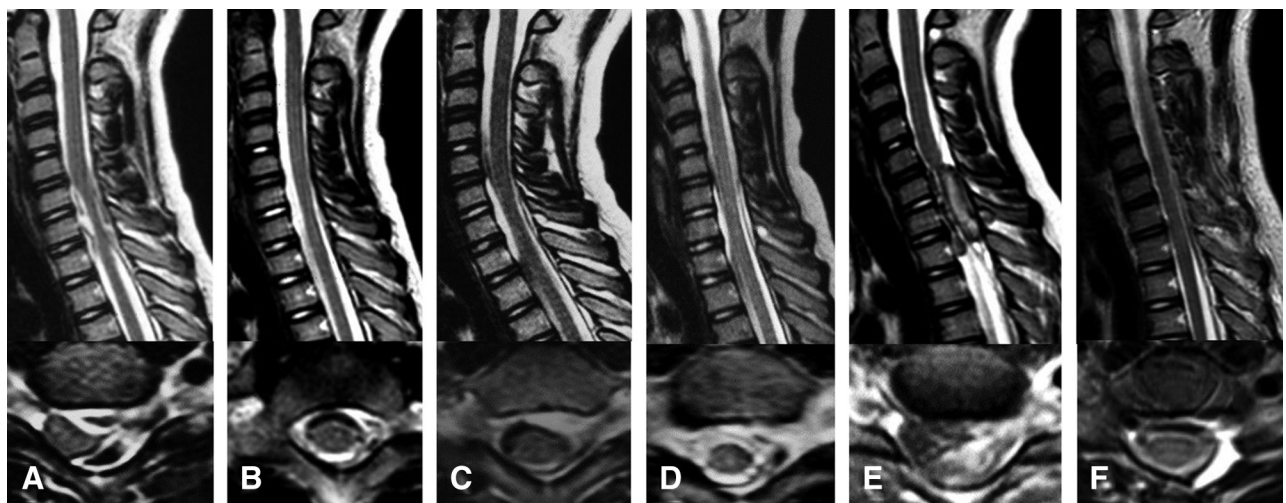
Serial cervical T2-weighted MRI of the C6/C7 vertebrae (sagittal view, upper; axial view lower). (A) At the time of the initial bleeding. These images demonstrate a SEDH on the left ventral and dorsal side of the spinal cord, which is severely compressing the spinal cord at the C6 to the T1 level. (B) One month after the initial bleeding. These images show decreasing SEDH. (C) Four months after the initial bleeding. Recurrence of the SEDH on the left ventral side of the spinal cord compression is observed. (D) Fifteen months after the initial bleeding. The third recurrence of SEDH is observed. (E) One week after the third bleeding event. These images show a third recurrence of the SEDH on the left ventral and dorsal side of the dural sac, similar to the first bleeding event. (F) Eighteen months after the operation, where the SEDH has been removed, and the spinal cord is now decompressed. SEDH: spinal epidural hematoma.
